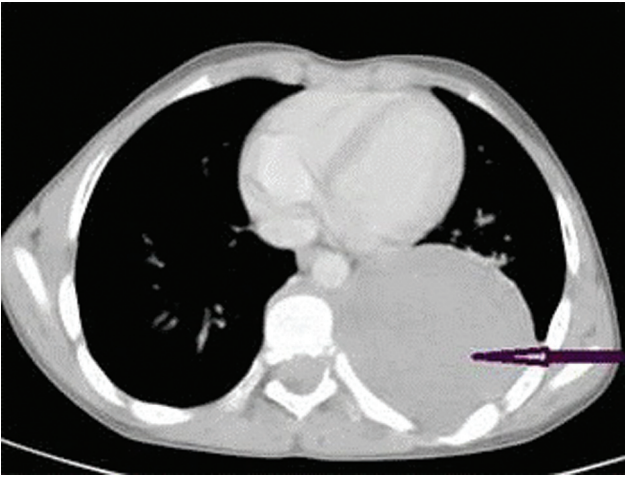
Axial contrast-enhanced computed tomography image demonstrating a poorly enhancing homogenous, soft-tissue attenuation mass (arrow) in left paravertebral region suggesting a diagnosis of neurogenic tumor.
